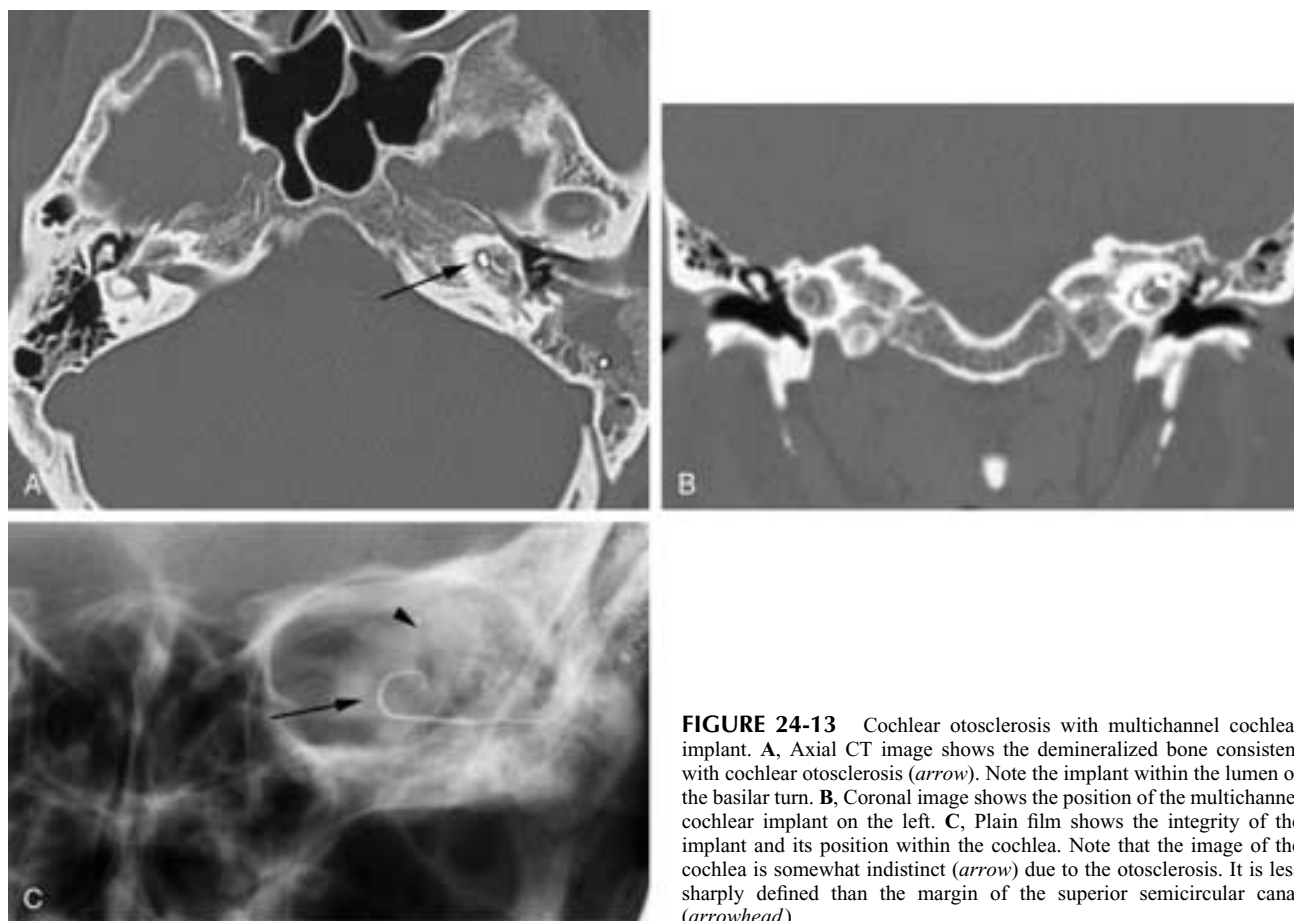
Cochlear otosclerosis with multichannel cochlear implant. A, Axial CT image shows the demineralized bone consistent with cochlear otosclerosis (*arrow*). Note the implant within the lumen of the basilar turn. B, Coronal image shows the position of the multichannel cochlear implant on the left. C, Plain film shows the integrity of the implant and its position within the cochlea. Note that the image of the cochlea is somewhat indistinct (*arrow*) due to the otosclerosis. It is less sharply defined than the margin of the superior semicircular canal (*arrowhead*).
